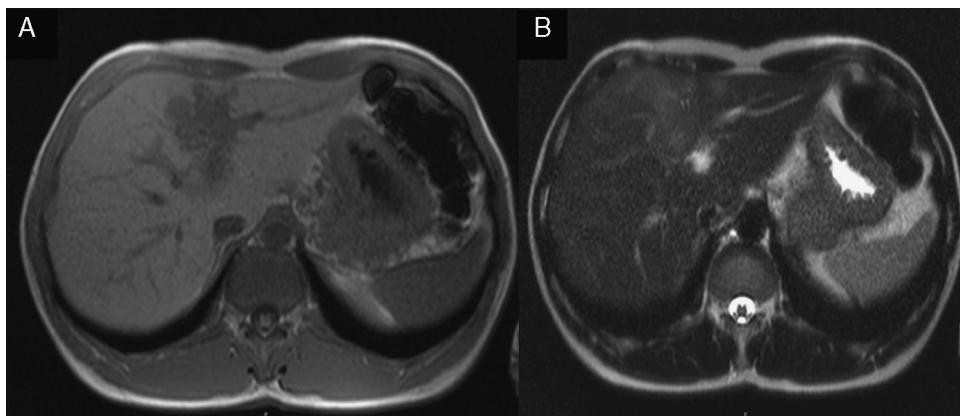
MRI: nodular lesion with lobulated and undefined limits, hypointense signal on T1 (A) and hyperintense signal on T2 (B).
